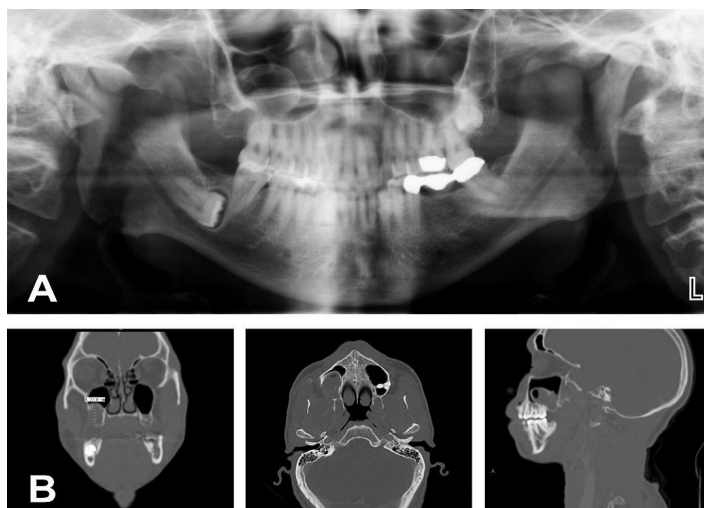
54-year-old African American male with ameloblastoma of right maxilla. Patient was asymptomatic until the tumor was discovered during a tooth extraction. Past medical history of controlled high blood pressure and permanent use of 2 antihypertensive medications. No consumption of tobacco or alcohol. BMI of 22 kg/m². Panoramic dental radiograph (A) and CT scan (B) demonstrated a 2.8 x 2.4 x 1.5 cm ameloblastoma centered in the posterolateral aspect of the right alveolar maxilla.
